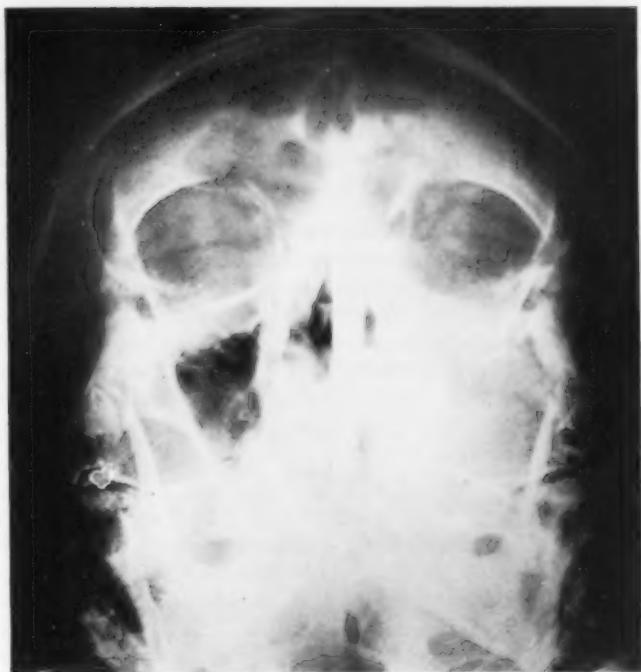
Carcinoma of left antrum. Anteroposterior roentgenogram showing opacity of antrum, involvement of ethmoid labyrinth, and erosion of superior, lateral and mesial antral walls. See also figures 22-A and B.
